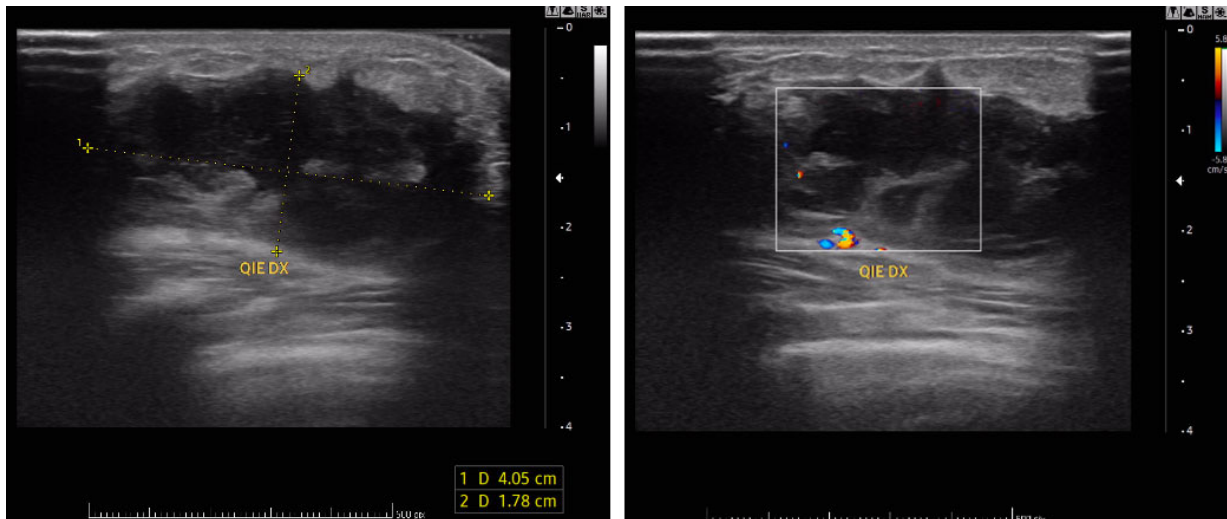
A 23-year-old female with Behçet's disease. The Ultrasound (US) image of the palpable nodule at the outer-lower quadrant of the right breast: (a) structural alteration with corpuscular fluid in the context (b) perilesional vascularity.
